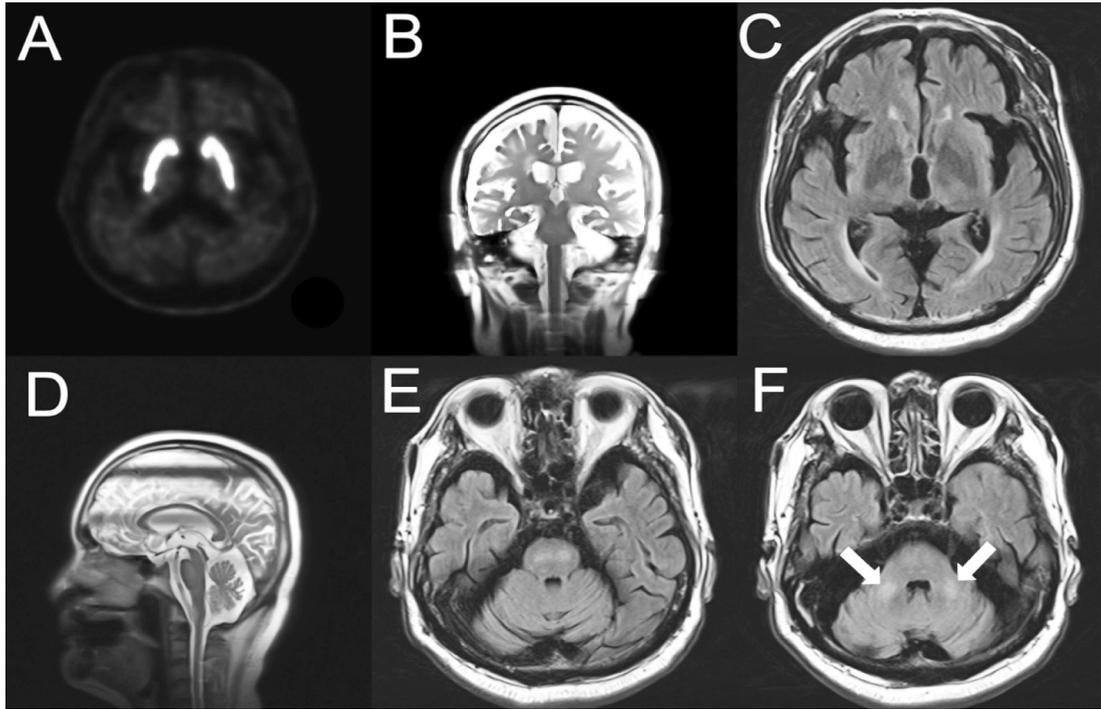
FP-CIT PET shows normal presynaptic uptake (A). Brain MRI reveals diffuse cerebral atrophy and subsequent prominent subarachnoid space (B, C). Cerebellar atrophy and pontine T2 high signal intensity are remarkable (D, E). T2 high signal intensity is observed in the bilateral middle cerebellar peduncles (F).
